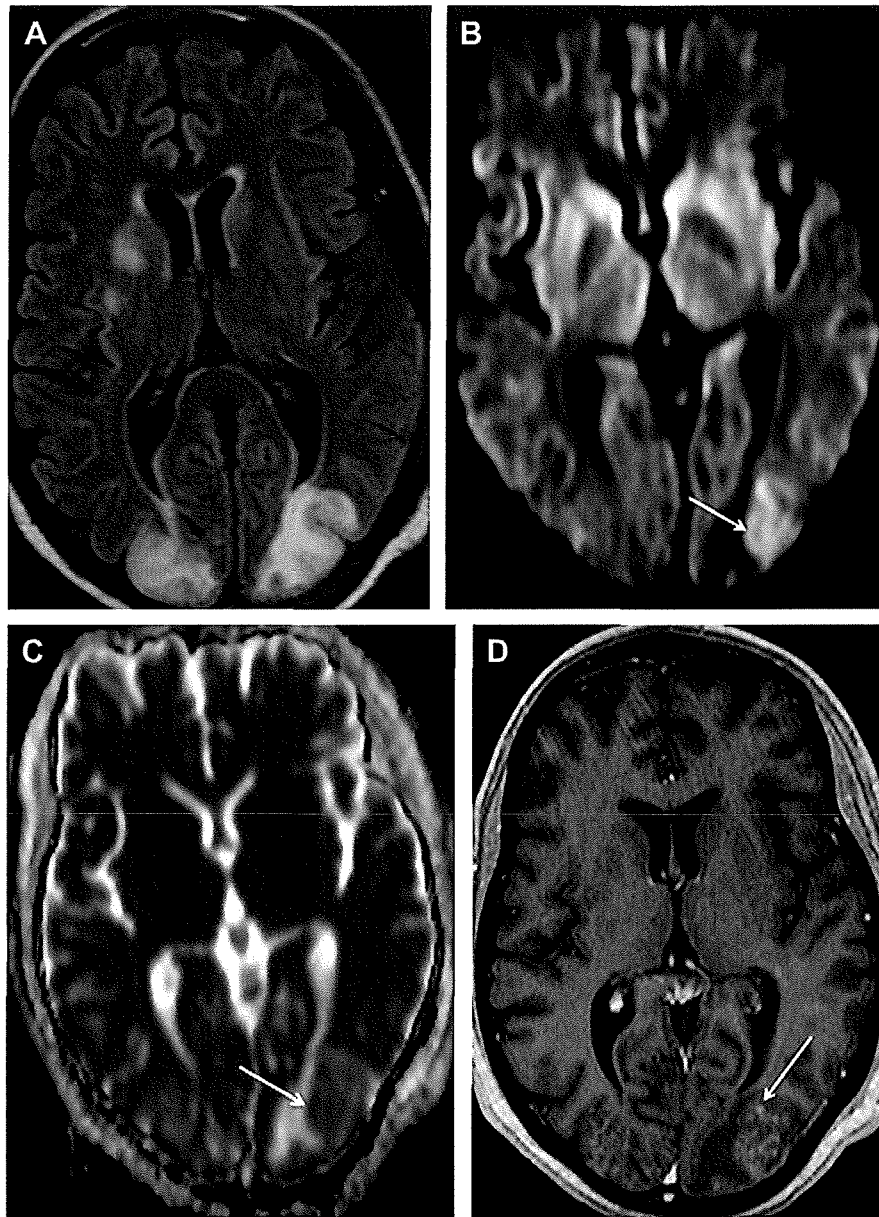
PRES with restricted diffusion and enhancement. Axial FLAIR image (A) shows cortical/subcortical FLAIR hyperintensity in the occipital lobes bilaterally as well as within the right basal ganglia. Axial diffusion-weighted image (B) shows an area of increased signal intensity in the left occipital lobe (arrow). Axial apparent diffusion coefficient map image (C) shows punctate focus of low signal (arrow) along the medial margin of the diffusion abnormality in the left occipital lobe consistent with a small focus of restricted diffusion next to a larger area of vasogenic edema with increased signal. Axial postgadolinium T1-weighted image (D) shows stippled enhancement (arrow) in the areas of FLAIR signal abnormality in the occipital lobes.
